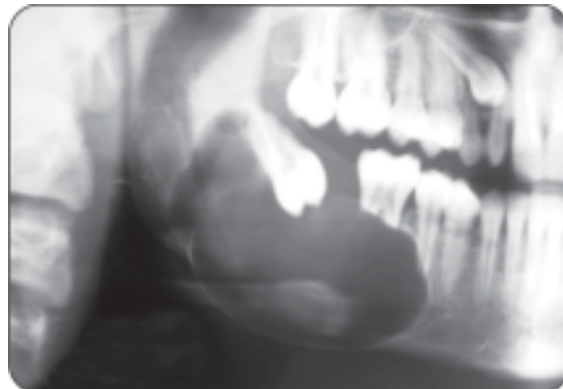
Radiograph of unicystic ameloblastoma
